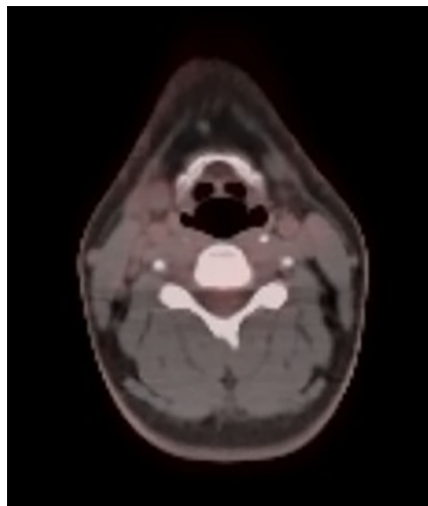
PET/CT 3 months following treatment demonstrating complete response.
